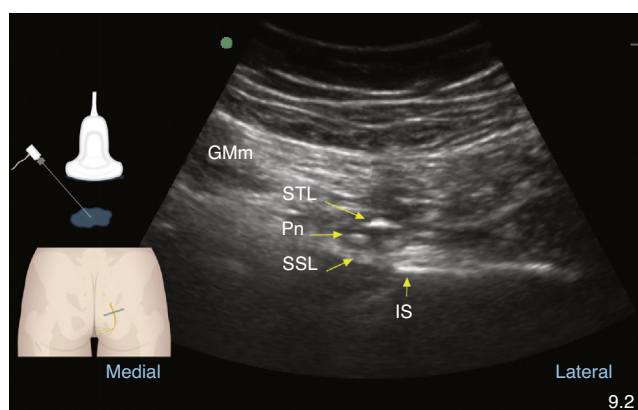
Gluteal ultrasound during pudendal nerve (Pn) recognition. The nerve is deep to the gluteus maximus muscle (GMm), the sacrotuberous ligament (STL), and superficial to the sacrospinous ligament (SSL). The ischial spine (IS) is found lateral to those structures. Source: Author.
